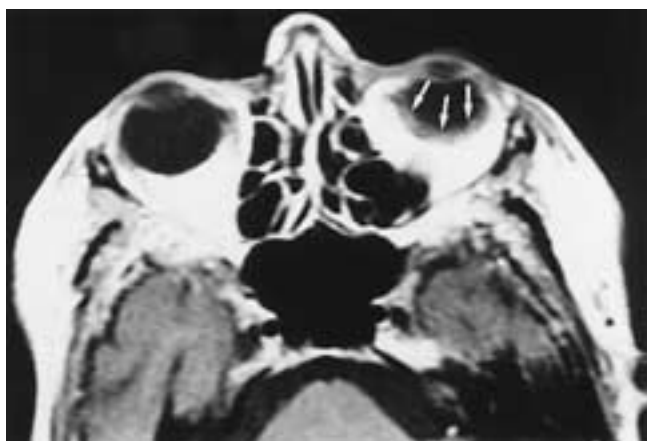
Choroidal lymphoma. Axial postcontrast T1-weighted MR image shows an irregular, infiltrative, moderately enhancing mass (arrows) involving the left globe. The appearance cannot be differentiated from that of uveal metastasis.
